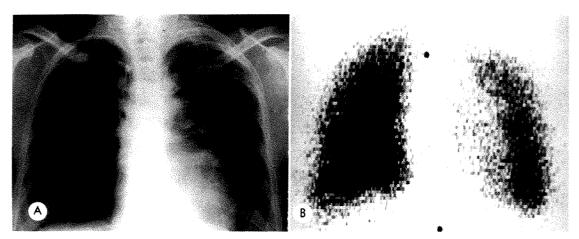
Ischemia and Radiation Fibrosis Following Remote Irradiation. Patient SB, a 31 year old female, had received tumor doses of 2,200 r in 20 days and 4,200 r in 45 days, 8 and 1 years before examination respectively. She had Hodgkin's granuloma involving the mediastinum. (A) Roentgenogram reveals paramediastinal fibrosis, chiefly left-sided. (B) Lung scan discloses moderately impaired perfusion of the entire left lung except in the lower third.
